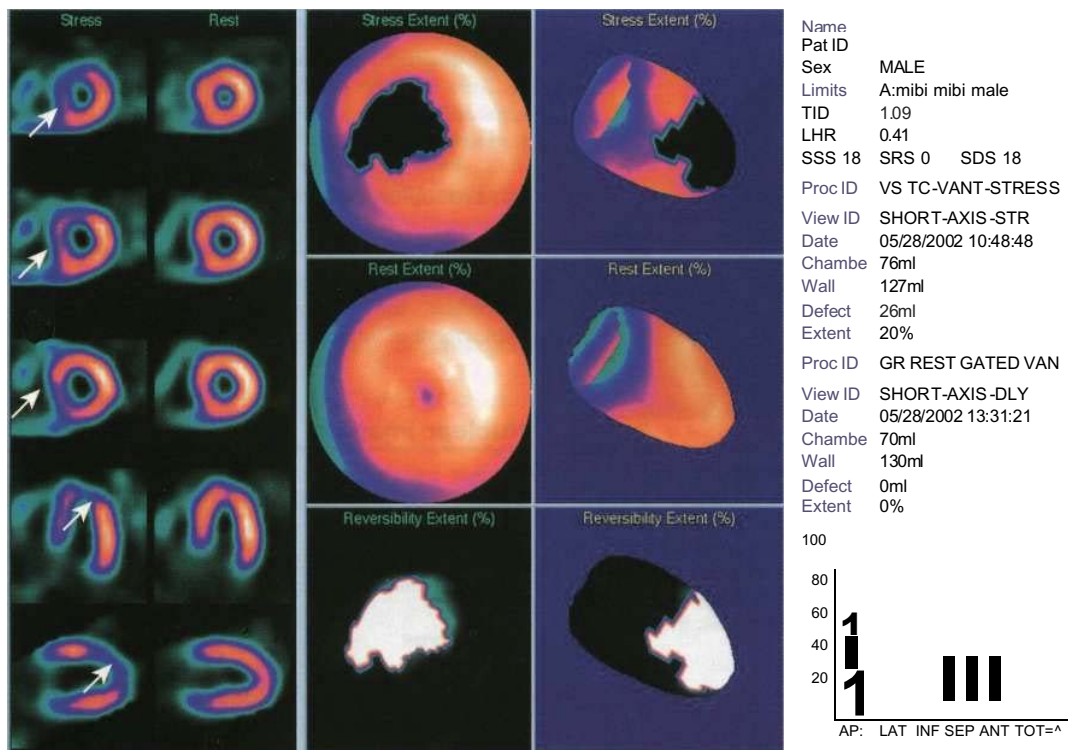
Myocardial SPECT study acquired with ^{99m}Tc tetrofosmin tracer. Left panel - three short axis slices, a horizontal and a vertical axis plane of the left ventricle after stress and following a resting re-injection of tracer. The rest images demonstrate normal tracer uptake (orange signal) in the whole of the left ventricle. The stress images demonstrate reduced tracer uptake (purple-blue signal) in the anterior and septal walls consistent with a significant stenosis in the left anterior descending artery. Middle panel - polar maps of the whole myocardium can localize the ischaemic territory. Right panel - quantitative analysis can help define the extent and reversibility of the ischaemia.
